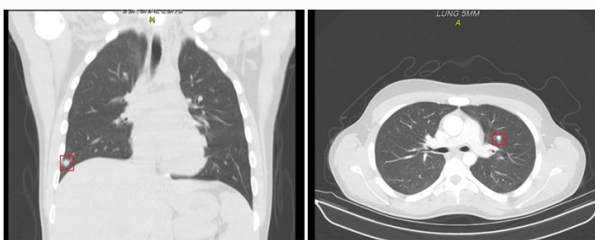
Multiple nodules are evident in different cuts of the lung CT scan.
